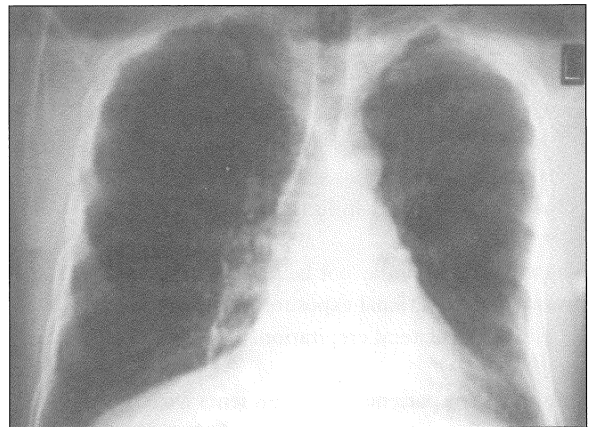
Chest radiograph of patient 2 showing pleural thickening, especially the left apex and base, shaggy heart borders and reticulo-nodular changes in the lung bases. The left lung apex also shows changes of old pulmonary tuberculosis.
